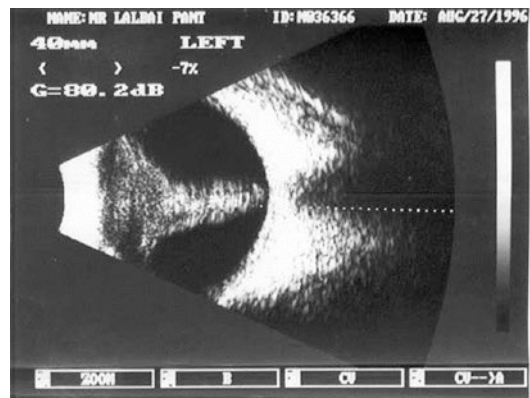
Ultrasound of the same eye as in Fig. 36.8 showing open funnel anteriorly and relatively narrow funnel open posteriorly
